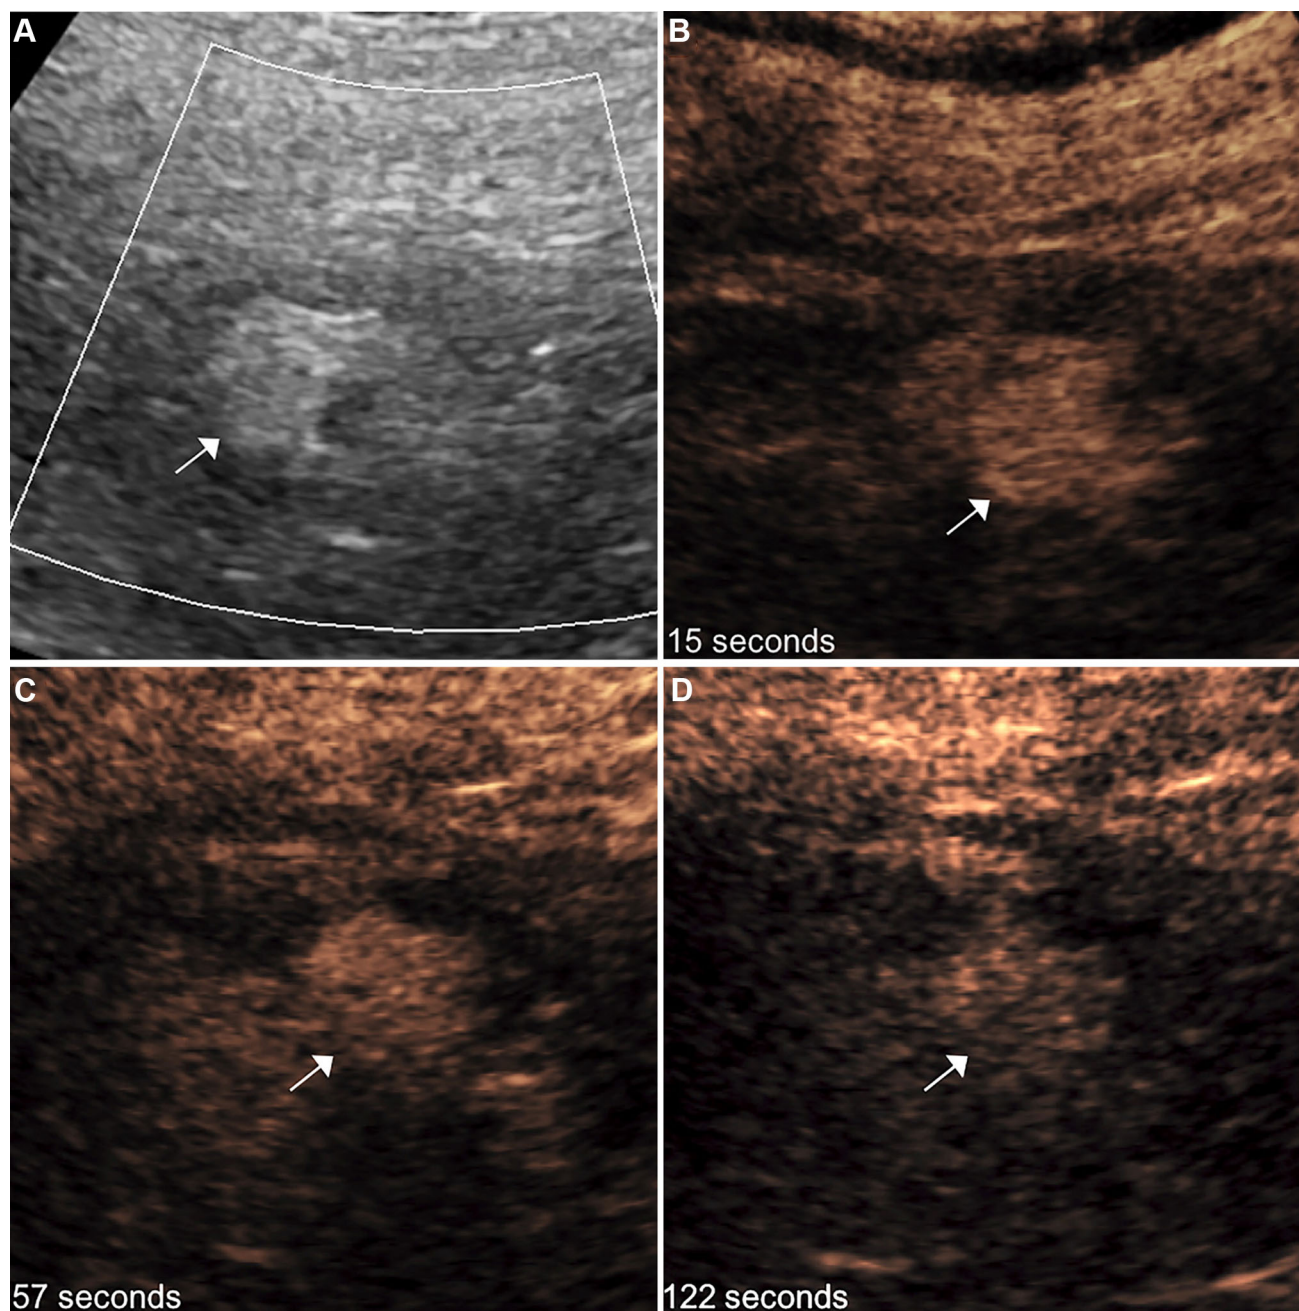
An 83-year-old female with a solid right renal lesion. A Color Doppler image of the right kidney reveals a hyperechoic lesion at the upper pole (*arrow*) without demonstrable internal vascularity. B CEUS obtained during the arterial phase (15 s) demonstrates early enhancement of this lesion greater than the background renal parenchyma (*arrow*).
